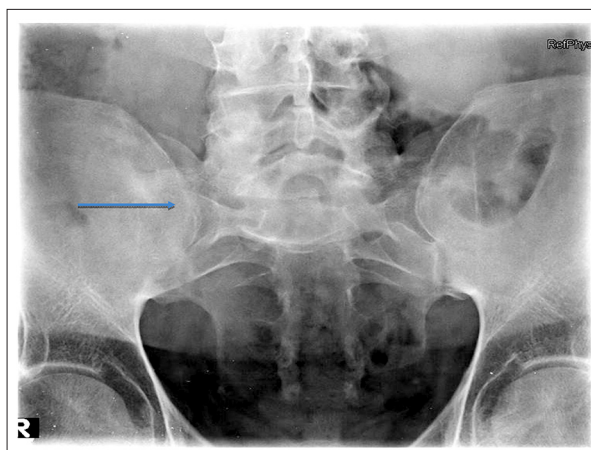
X-ray of the sacroiliac joint shows bilateral sacroiliitis (arrow) with decreased joint space and bony fusion.
